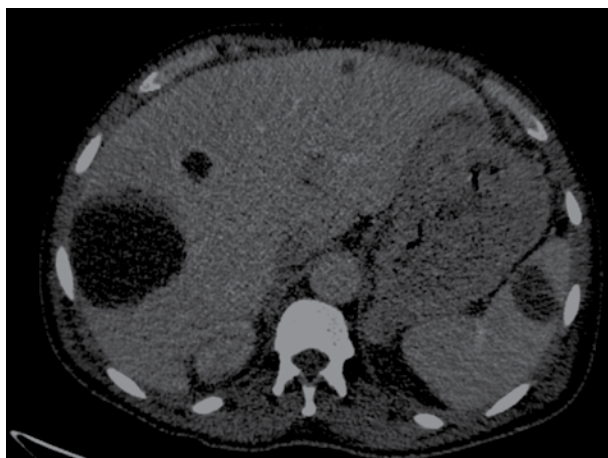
CT scan of the abdomen. Hepatic and splenic cystic lesions are present.
